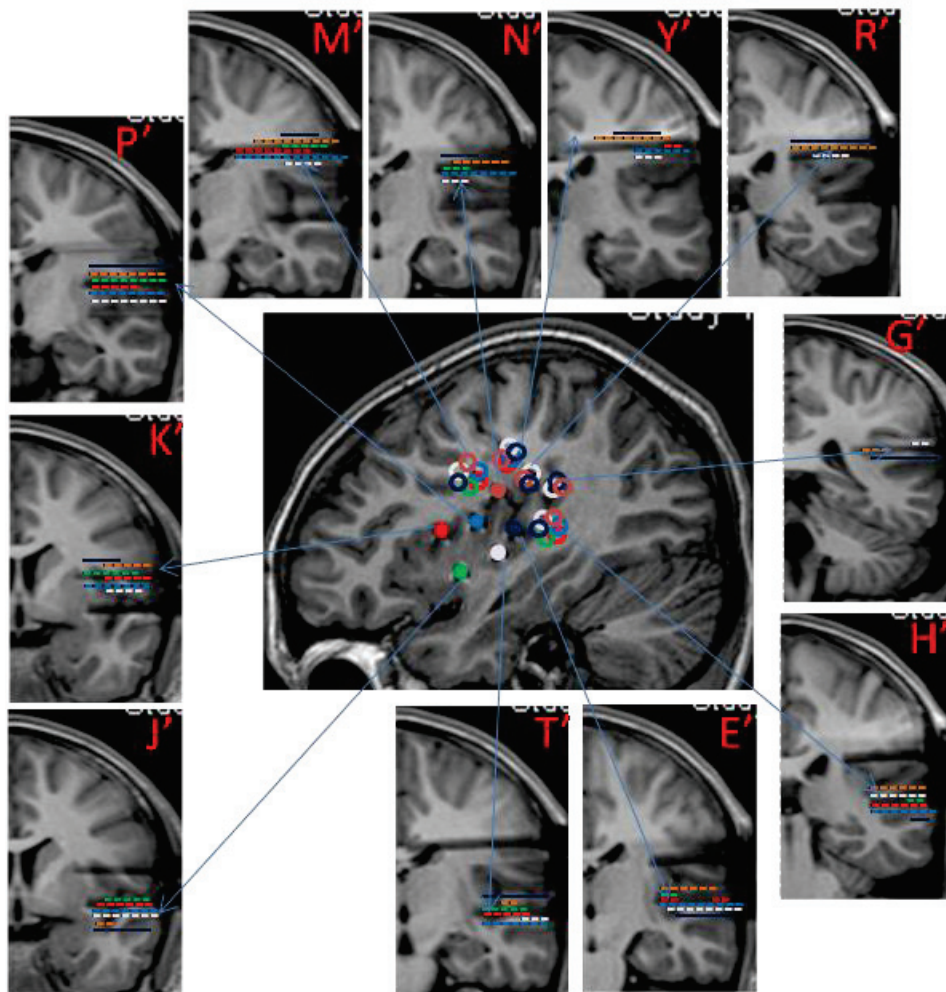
3: Patient 3 MRI with electrodes in place. (Left hemisphere). Central sagittal image: each insular electrode is represented by a unique colored solid circle; non-insular electrodes are represented by empty circles with the color of each of the insular electrode they are responding to. Yellow solid circles are for non responding electrodes. Peripheral coronal images: a cross-section of each electrode with its name and its responding contacts (responses are indicated by color coded dotted lines, representing the color of the corresponding stimulated insular electrode).
